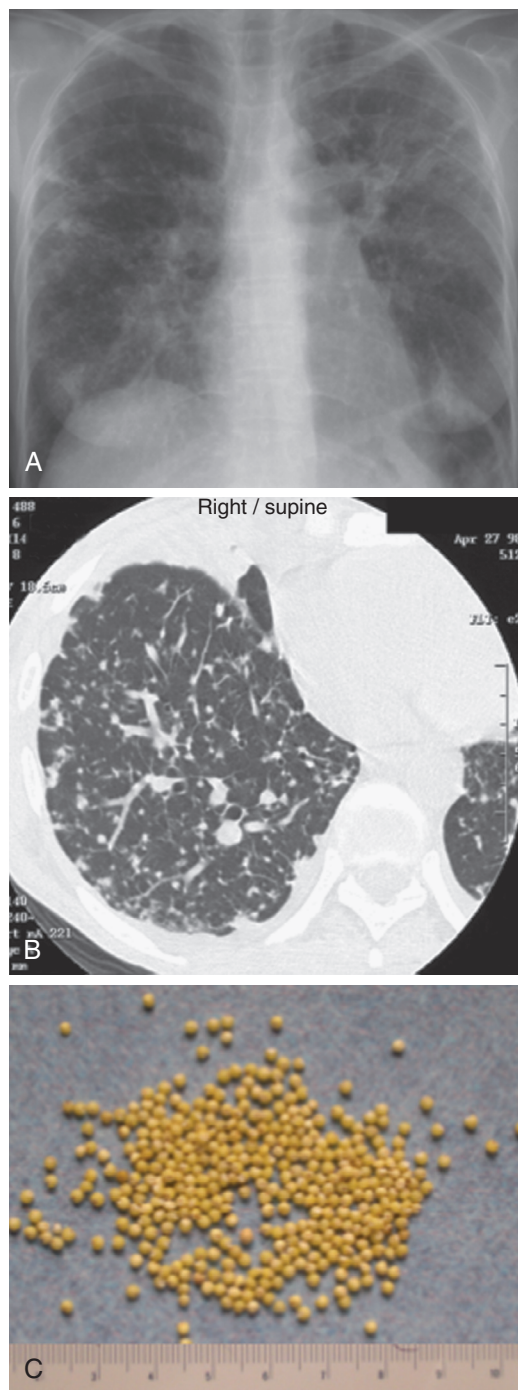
■ Miliary TB. A, Chest radiograph of a patient with miliary TB. B, The chest CT scan of the same patient. Both show the characteristically small, less than 2-mm, nodules that are supposed to resemble (C) millet seeds. Note that millet seeds are approximately 2 mm in diameter.
